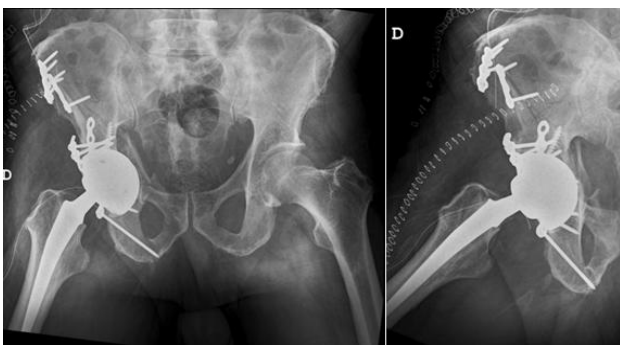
Postoperative radiograph after primary THA, which was performed in conjunction with an ORIF.
